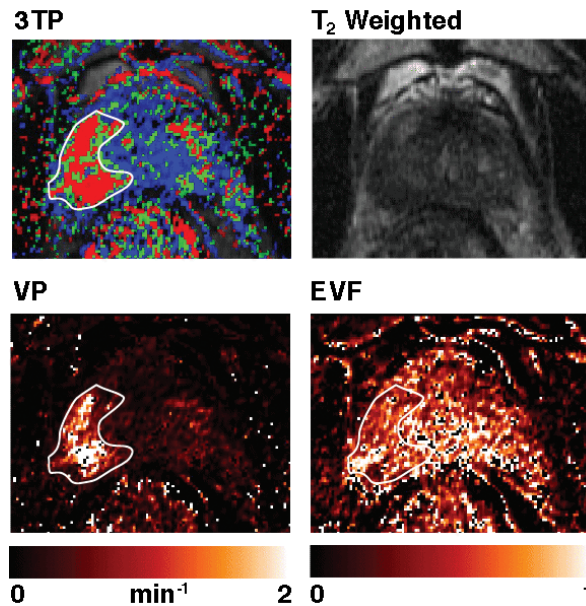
Parametric MRI of the prostate. The tumor is characterized by high vascular permeability (VP) and heterogeneous extracellular volume Fraction (EVF). The 3TP image delineates better tumor margins.
